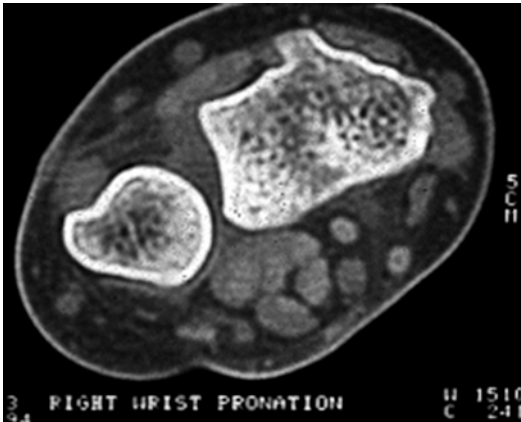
CT scan showing volar subluxation
